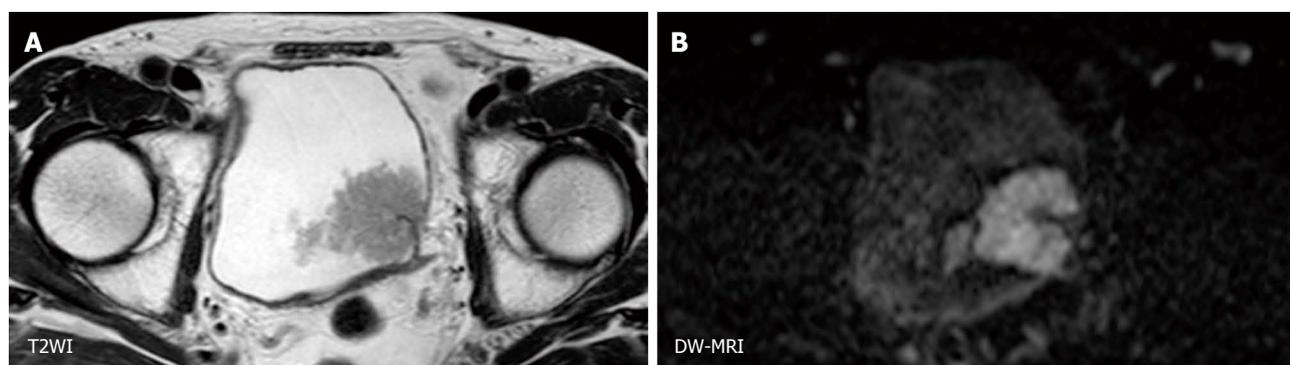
Magnetic resonance images of a 63-year-old man with non-muscle-invasive bladder cancer (urothelial cancer, stage pT1, grade 2 > 3). A: T2WI shows a large papillary tumor on the left bladder wall; B: DW-MRI displays a C-shaped high-signal tumor with a low-signal-intensity stalk connecting to the bladder wall. This C-shaped high signal is known as an "inchworm sign", which is a criterion for T staging in non-muscle-invasive bladder cancer (stage cT1 or less). DW-MRI: Diffusion-weighted magnetic resonance imaging.
